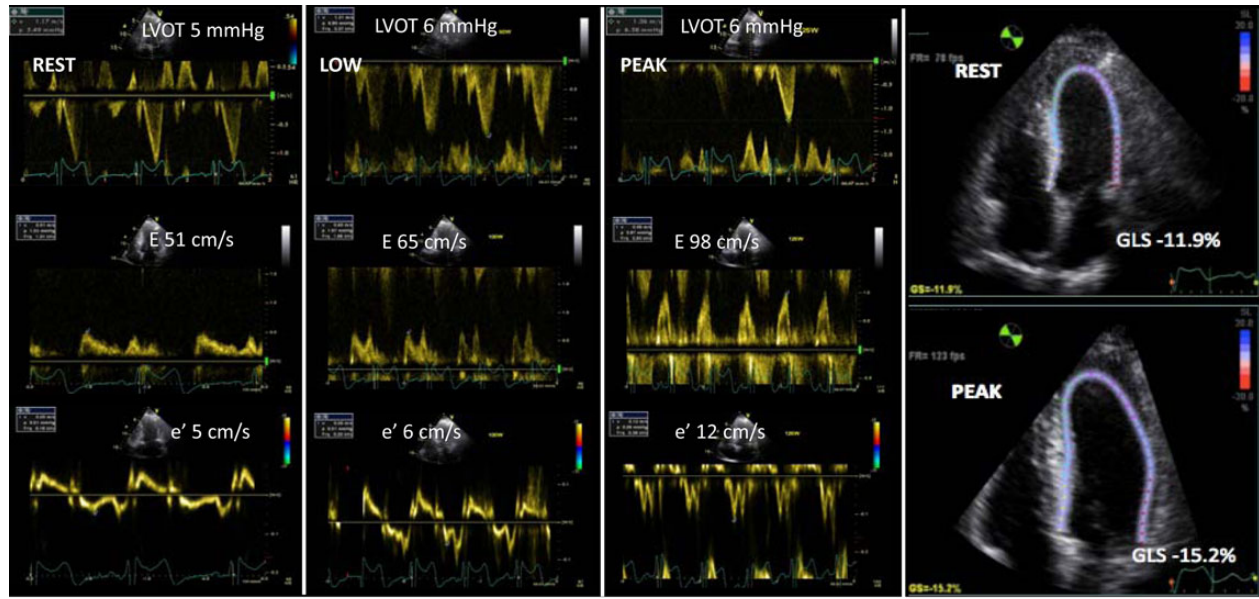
Breathless patient with HCM and chronic obstructive pulmonary disease. Exercise echocardiography reveals the presence of systolic (increase in global longitudinal strain [GLS]) and diastolic (increase in e') reserve without significant increase in E/e' (left ventricular filling pressure). These data suggest that the symptoms are mainly due to the pulmonary disease.
